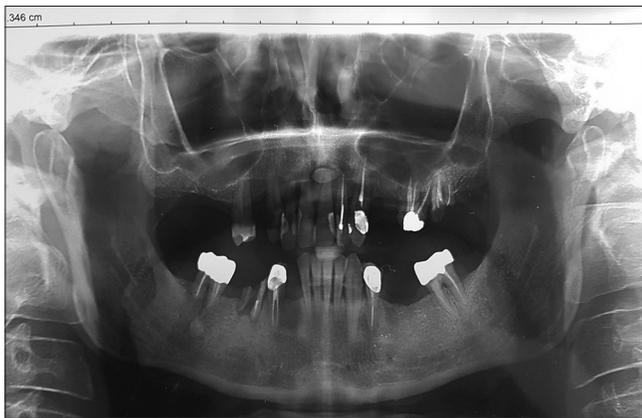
Preoperative panoramic radiograph showing edentulous spaces, profound periodontal involvement, teeth with paro/endo defects, root resorptions, and incomplete root-canal treatments. In this image (tomography), the elongation of the maxillary anterior bone segment is not visible. Certainly, it would be possible to repair single teeth for a number of times still. The "big picture" however shows that bilateral and equal mastication on teeth is not possible if these teeth are used
